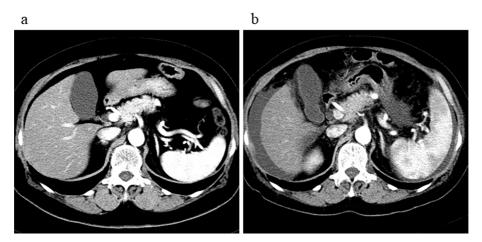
Abdominal computed tomography scans. Although ascites, liver atrophy and splenomegaly were not observed at the initial examination (a), these findings were observed three years later (b).
